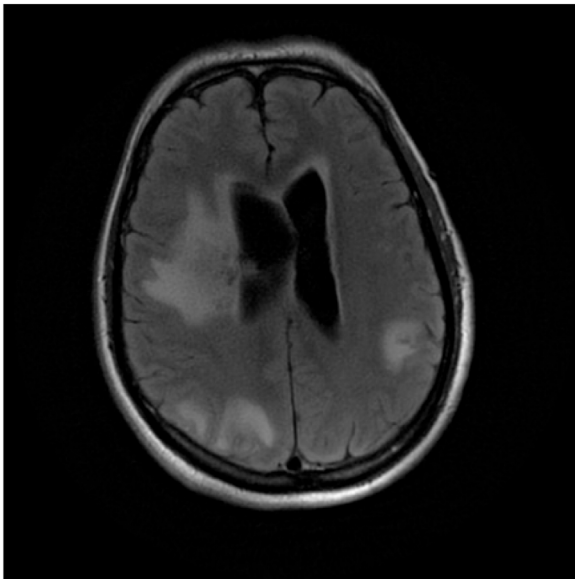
Diffuse cerebral edema on MRI FLAIR.
